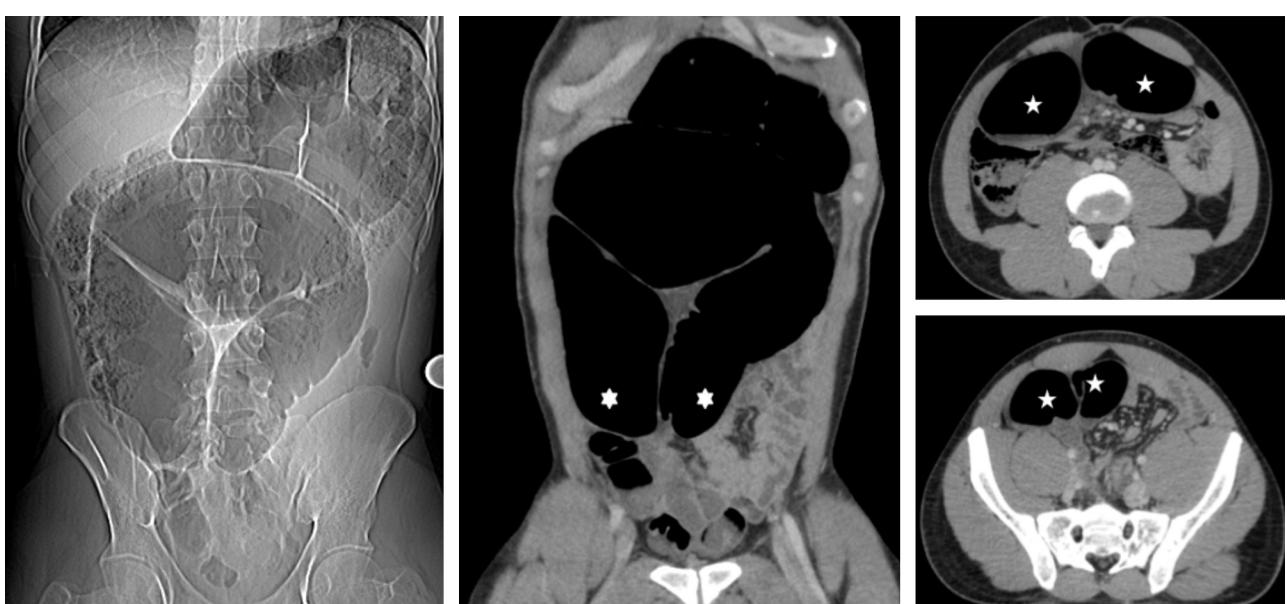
Mesenterico-axial volvulus of the sigmoid. "Coffee bean" image abdominal pain film (a). Coronal (b) and axial CT image (c, d): convergence of 2 sigmoid descenders (asterix) towards the place of torsion.
